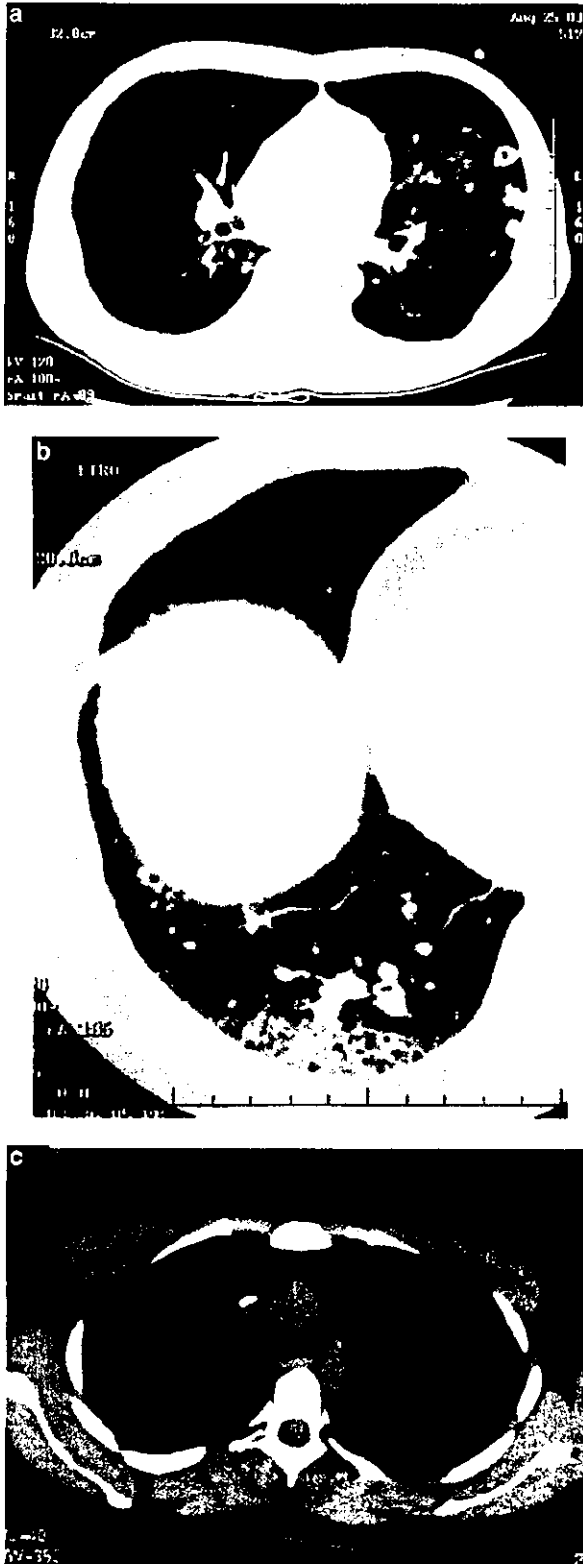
Chest CT scans. (a) Patient 1: follow-up CT on day 75 showed multiple cavities in bilateral lungs, which were 12mm in diameter. (b) Patient 2: chest CT on day 34 showed infiltration in the right lower lobe, thickening of bronchial wall and pericardial effusion. (c) Patient 3: enlarged mediastinal lymph nodes.
